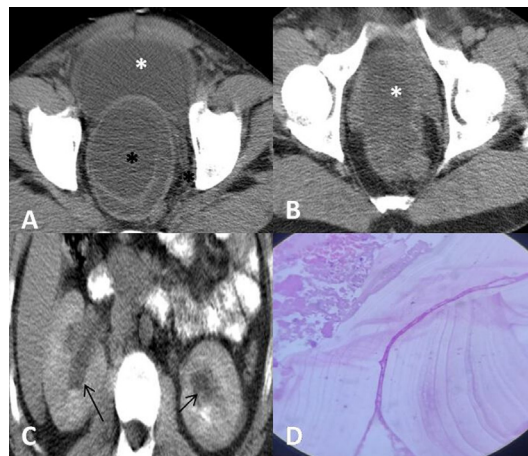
Axial sections from contrast-enhanced CT abdomen (A) a large, well-defined cystic lesion with internal septations (hydatid cyst, black asterisk) pushing the bladder anteriorly (white asterisk). The lesion is causing bladder neck compression (B, white asterisk) and resultant hydroureteronephrosis (C, black arrows). (D) 40× histo-pathological examination (HPE) image from the surgical sample showing laminated cystic wall comprising of endocyst, ectocyst and pericyst surrounded by fibroblastic tissue.
